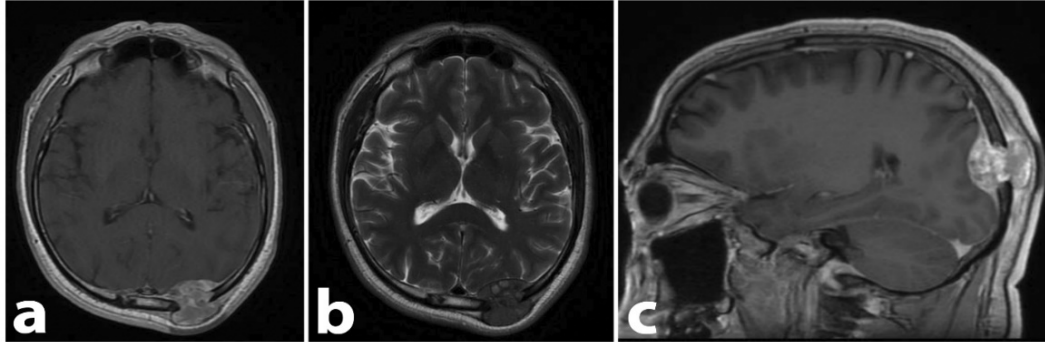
Preoperative MRI. a) T1WI with gadolinium, axial image, evidencing a left occipital lesion, extending from the intracranial to the extracranial compartment, eroding the adjacent bone, with heterogeneous enhancement by contrast. b) T2WI, axial image, evidencing the hypointense left occipital lesion, with apparent cleavage plane from the brain tissue. c) T1WI with gadolinium, sagittal image, evidencing a left occipital lesion, extending from the intracranial to the extracranial compartment, eroding the adjacent bone, with heterogeneous enhancement by contrast.
